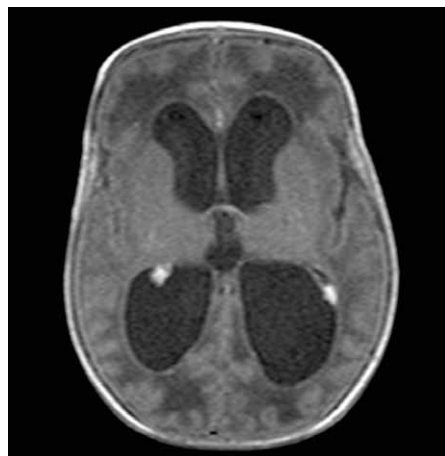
Cerebral computed tomography - IV degree IVH
